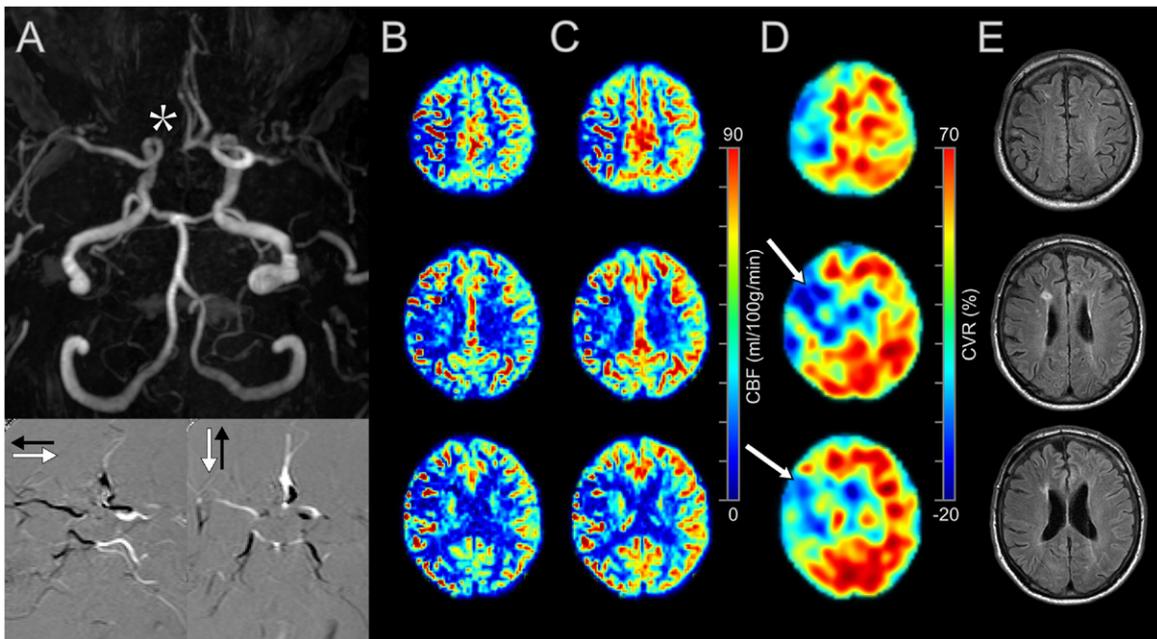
Example of 67-year-old patient with a right-sided ICA stenosis. MR time-of-flight image and flow direction angiography (A) shows a missing pre-communicating segment (A, star) of the right anterior cerebral artery. Before (B) and after (C) the acetazolamide reactivity challenge an increase in CBF in the left hemisphere is observed in the ASL MRI perfusion images. The right hemisphere shows large areas with a CBF increase but a decrease in CBF is observed centrally in the right hemisphere. The percentage reactivity image (D) shows the absence of reactivity in the central area of the right hemisphere with hemodynamic steal in the dark blue area (D, arrows) corresponding with a decrease in CBF. FLAIR MRI images (E) show no infarct in this region although a small hyperintense lesion is seen next to the frontal horn of the right ventricle.
